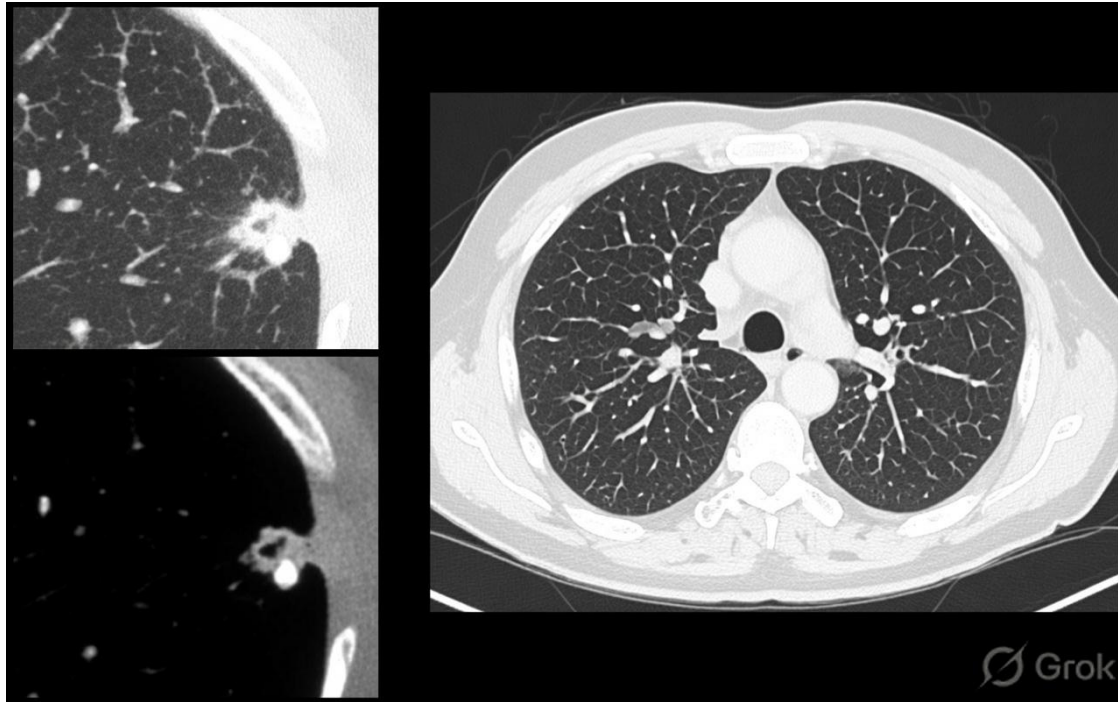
Axial CT images of the chest demonstrating well-defined pulmonary nodules, some containing coarse calcifications. In the appropriate clinical context these findings are consistent with pulmonary chondromas, a key component of Carney triad.
